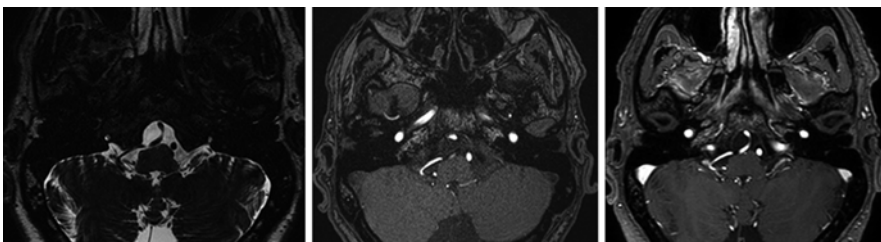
From left to right, high-resolution T2, TOF angiography, and T1 + gadolinium MRI sequences showing neurovascular conflict between the IXth nerve (*arrow head*) and posterior inferior cerebellar artery [PICA] (*arrow*)
